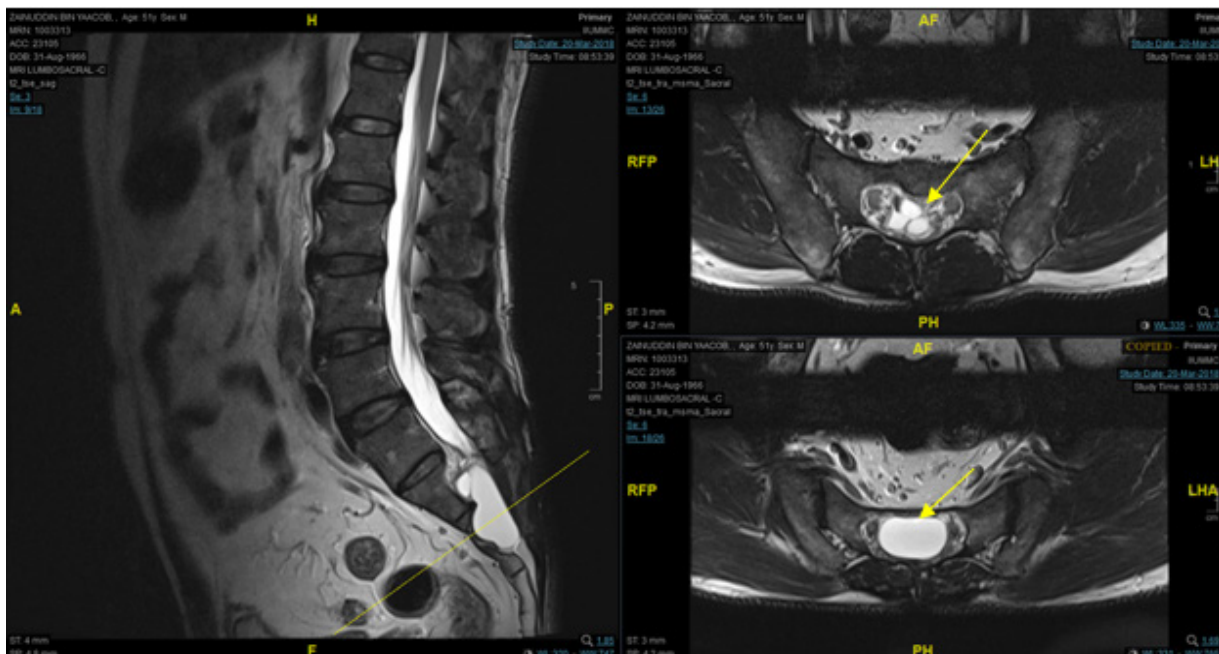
T2-weighted lumbosacral MRI images. Sagittal (a), axial (b, c) views show the well-defined multiloculated cystic structure which follows cerebrospinal fluid signal intensity (yellow arrow) at the S1 vertebra (b) and the cyst (yellow arrow) at S2 vertebra (c). Preoperative magnetic images demonstrating a hyperintense lesion in T2-weighted MRI.
